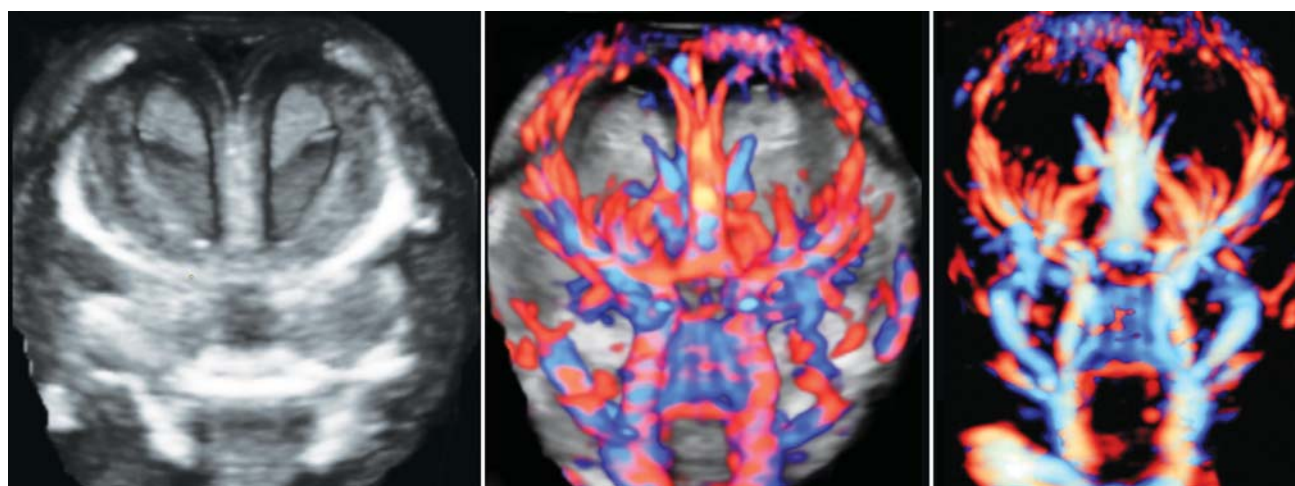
Brain circulation at 14 weeks by 3D bidirectional power Doppler. (Left) Volume contrast imaging in coronal cutting section. (Middle) 3D bidirectional power Doppler reconstructed image with B-mode. (Right) Brain angiography by 3D bidirectional power Doppler. These three images are obtained by a single acquisition
